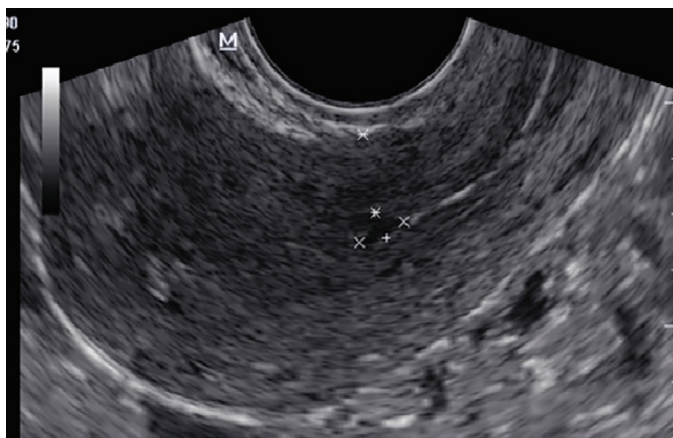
Transvaginal ultrasound image of the uterine niche in a patient undergoing cesarean for the first time
